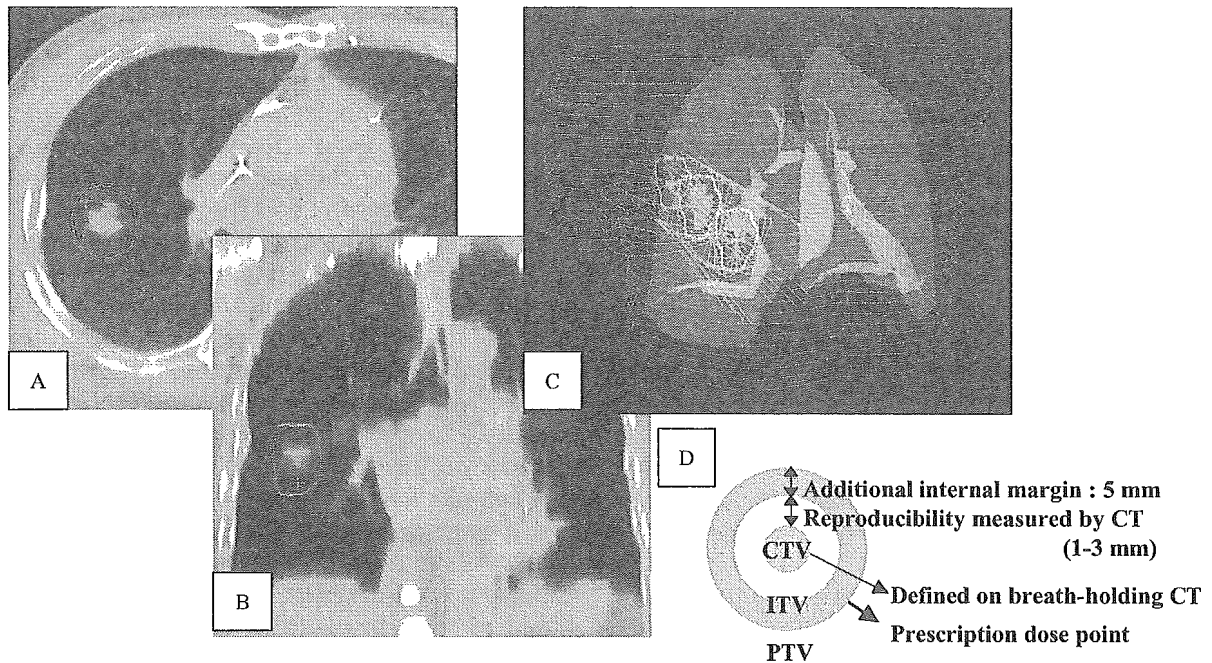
Three-dimensional treatment planning. Prescribed dose was calculated at the 80% line of global maximum dose in the planning target volume. The 80% isodose line accords with the third line from inside. (A) Isodose curves on axial CT through the center of the PTV; coronal reconstructed image through the center of the PTV. (B) Isodose curves on a coronal reconstructed image through the center of the PTV. (C) Three-dimensional image showing all radiotherapy arcs and isodose curves. (D) Definitions for the internal target volume (ITV) and PTV.
